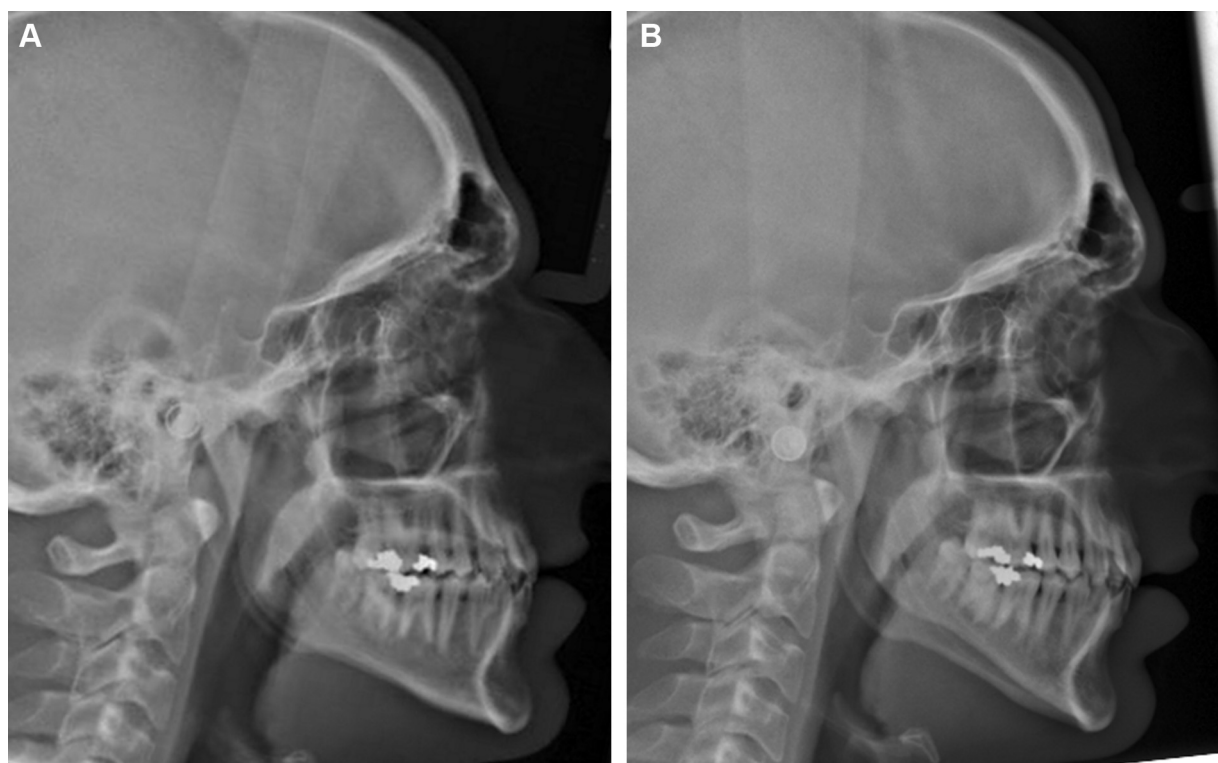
Lateral radiographs of a 23-year-old patient A, before and B, 23 months after proportional condylectomy. A double contour of the lower border of the mandible is evident in the postoperative radiograph, corresponding to the vertical asymmetry developing after proportional condylectomy. In addition, the slight mandibular setback is evident when comparing the postoperative with the preoperative radiograph.
